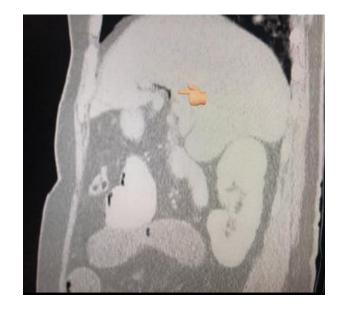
Abdominal CT scan, coronal plane, portovenous phase. A hypodense linear tract at the anatomical site of common bile duct and common hepatic duct due to existence of gas in the biliary tract (pneumobilia)
